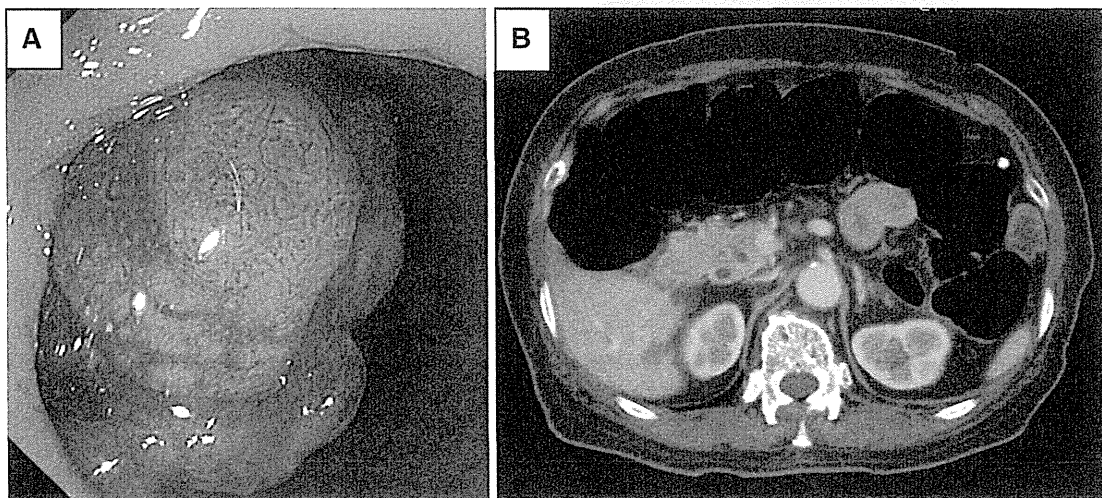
The colonoscopy and CT for Case 1. a Colonoscopy revealed a rectal tumor. b The CT scan showed a metastatic tumor in S6 of the liver
